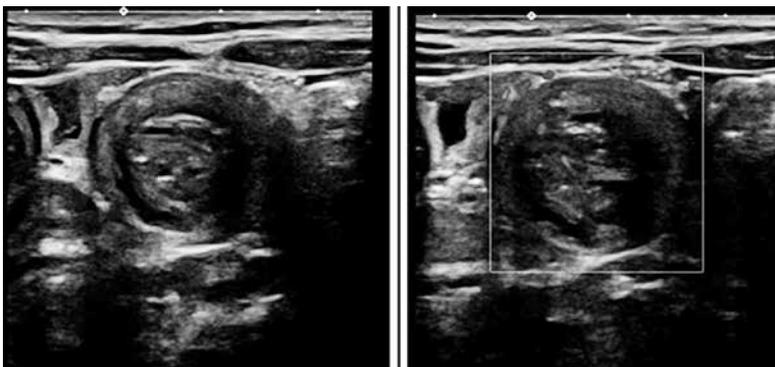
The ultrasound features seen with successful reduction of intussusception i.e., no trapped inter bowel loops fluid and normal Doppler flow in bowel wall.
